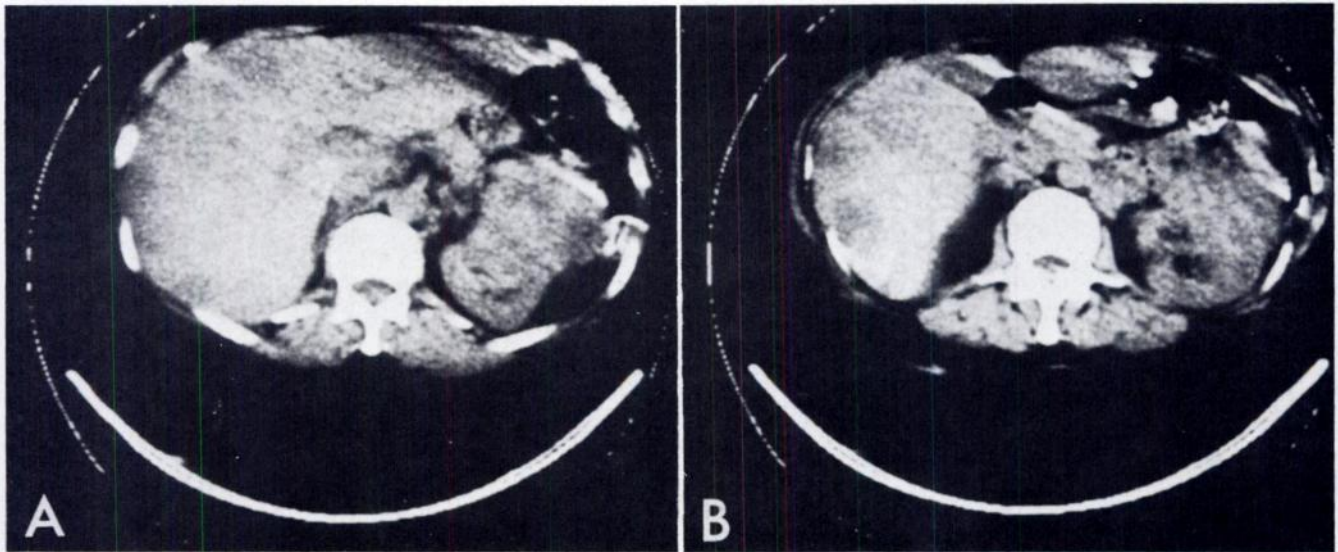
CT scans showing hepatic metastasis from renal carcinoma. Discovered during CT evaluation of suspected hepatic abscess. Multiple mass lesions in liver typical of metastasis; large mass arising from anterior aspect of left kidney characteristic of renal cell carcinoma. Note inhomogeneous density of renal tumor and absence of well defined interface with renal parenchyma.
